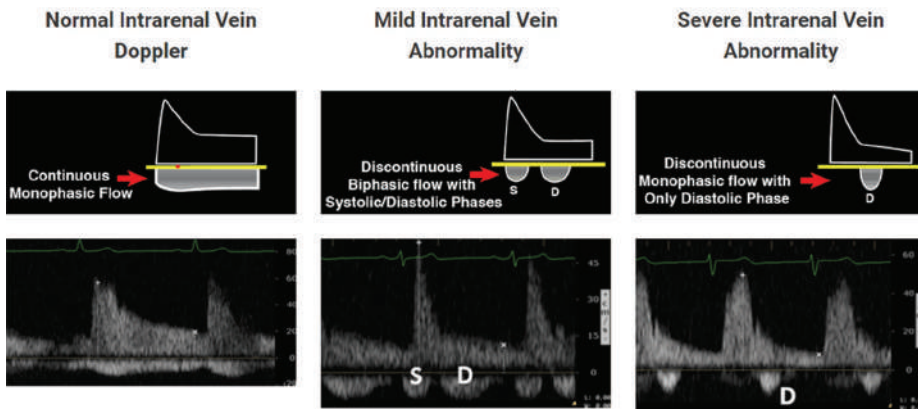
Intrarenal vein doppler.
